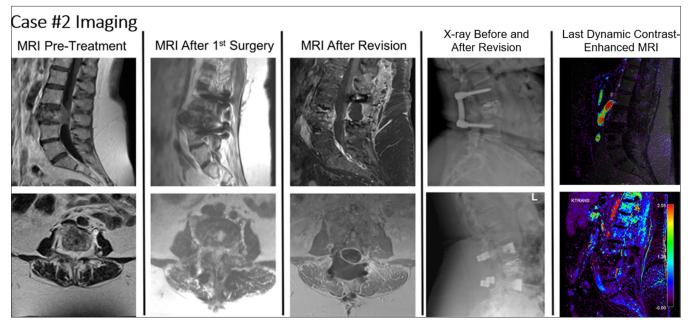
Relevant imaging for Case #2. The first column contains T1-weighted fat-suppressed magnetic resonance imaging (MRI) pretreatment (top = sagittal, bottom = axial). The second column contains T1-weighted fat-suppressed MRI after her first surgery (top = sagittal, bottom = axial). The third column contains T1-weighted fat-suppressed MRI after her revision surgery (top = sagittal, bottom = axial). The fourth column contains sagittal X-rays before (top) and after (bottom) revision surgery. The last column contains the last dynamic contrastenhanced-MRI (top = overlay, bottom = MR perfusion).
